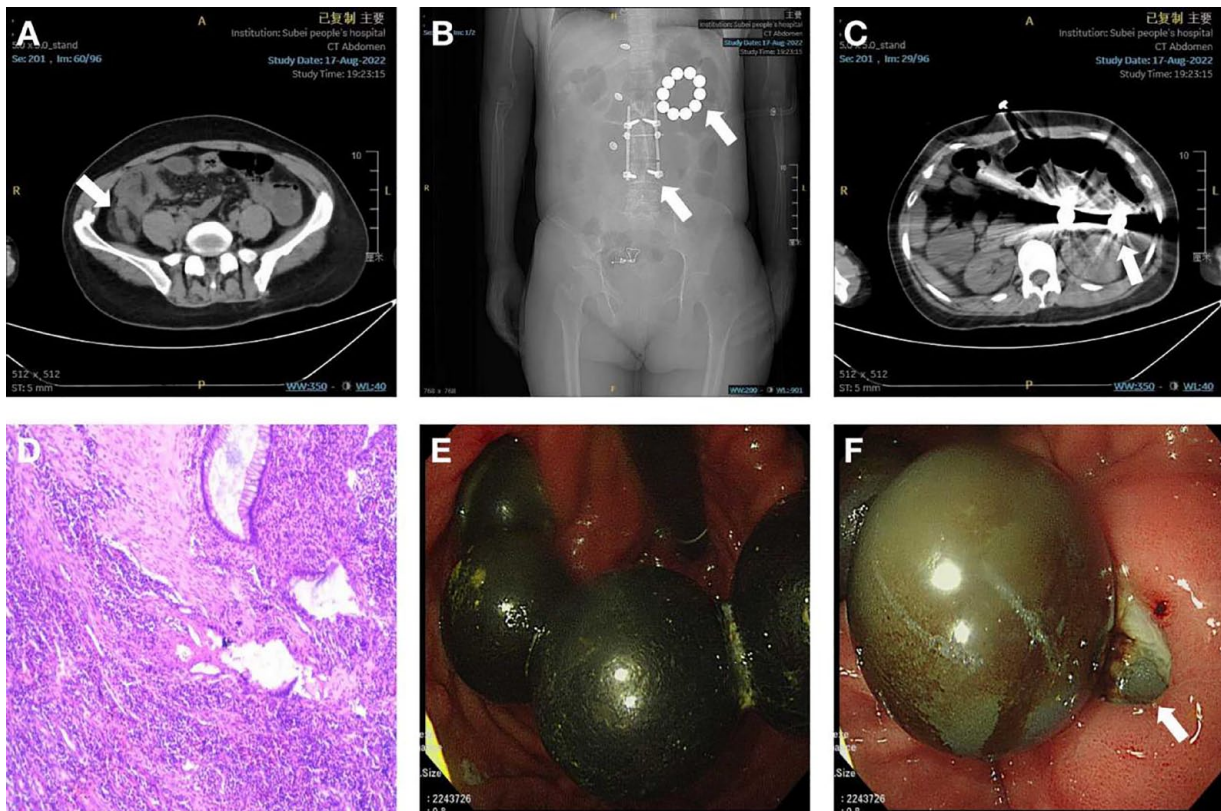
Images obtained from CT scan, pathology, and endoscopy: (A) CT scan shows acute appendicitis, (B) upper arrow shows a bead bracelet was observed in the left upper diaphragm area; lower arrow shows an intramedullary nail fixation in the lumbar vertebrae, (C) CT scan shows the beaded foreign bodies were in the left middle and upper abdomen, surrounding radial artifacts are large, and the adjacent structures were not clearly displayed, (D) pathological image of appendicitis, (E) several independent metal spherical objects were observed the moment when the endoscope reached the gastric cavity, and (F) one of the beads was embedded deep in the gastric mucosa.
